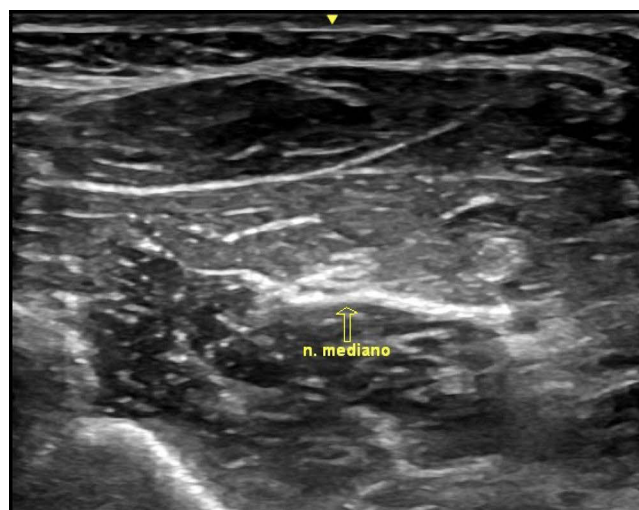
Use of ultrasound to locate the median nerve for the application of the percutaneous neuromodulation intervention.
